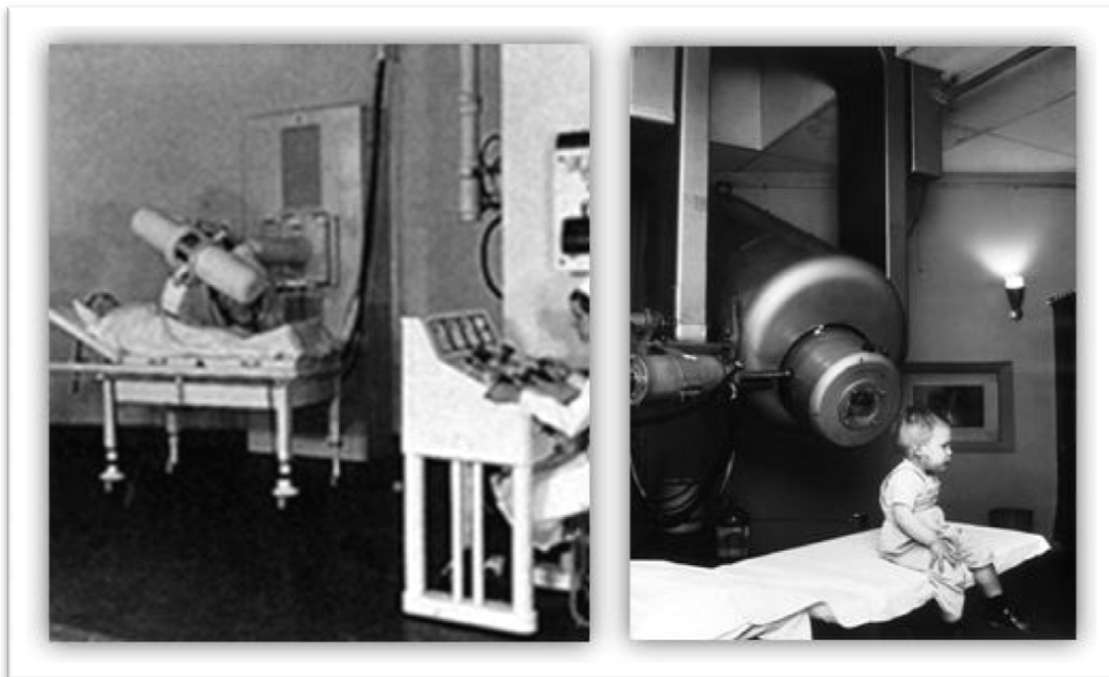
On the left: An original X-ray cancer therapy system in use circa 1922 (22). On the right: A two-year-old boy suffering from retinoblastoma, was the first patient to be treated using a research linear accelerator modified by physicists for medical use, in 1957 (23). A year later, was introduced the first commercial medical-use linear accelerator.
